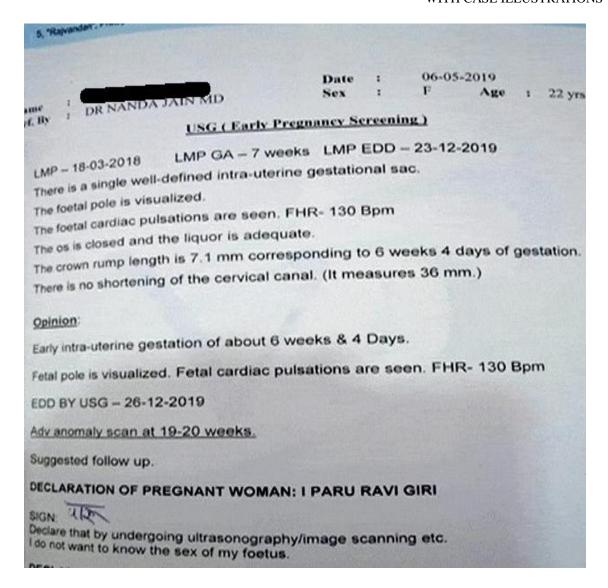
Ultrasonography findings after Homoeopathic treatment – Case-3
